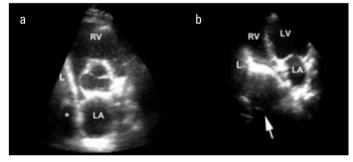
a, b. (a) (asterisk) and Video 1 show right atrial compression by a radiolucent mass in the parasternal short-axis view of TTE. (b) (arrow) and Video 2 show right atrial compression by a radiolucent mass in the apical four-chamber view of TTE
